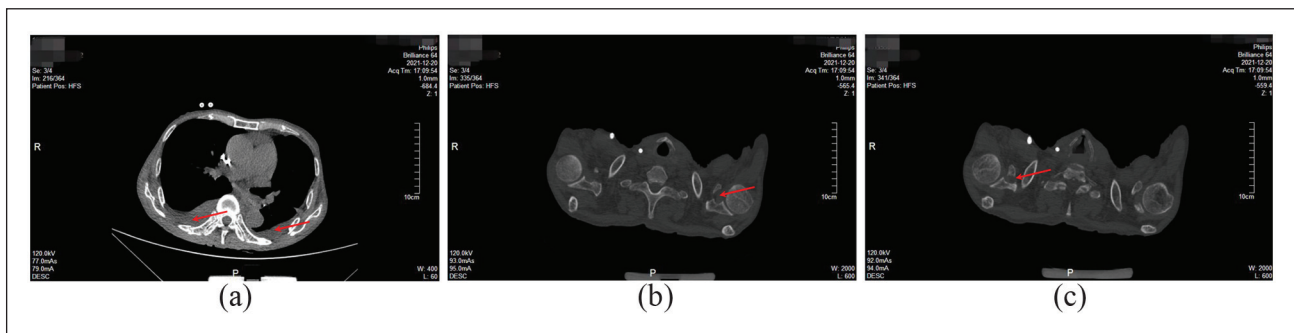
CT scan on 20 December 2021, yet indicating bilateral pleural effusion (a, red arrows) and bilateral coracoid process fracture. The fracture did not heal (nonunion), and sclerosis was present at the broken ends without bone destruction (b and c, red arrows).
